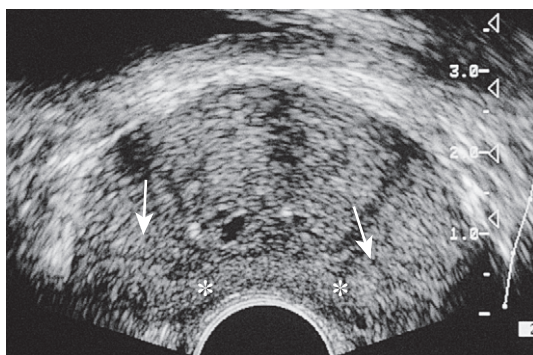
Axial ultrasound of the prostate in a normal patient. Note peripheral zone (*) separated from the more centrally oriented, periurethral, transition zone by the surgical capsule (arrows).
